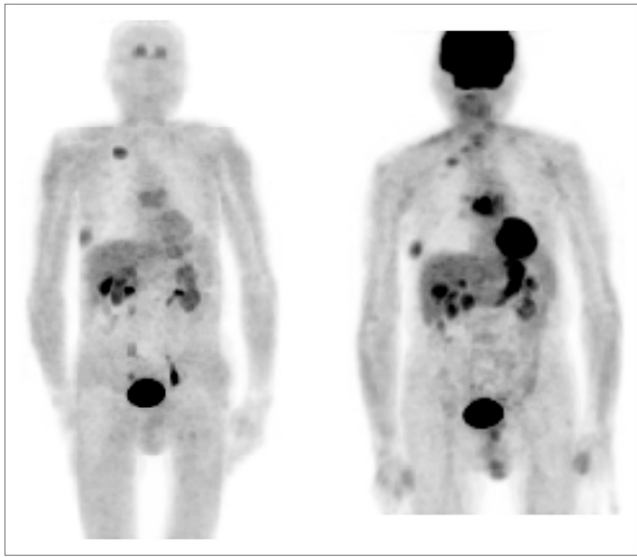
MTC patient with uptake on both ^{18}F -DOPA PET (left) and ^{18}F -FDG PET (right). On ^{18}F -DOPA PET, lesions are seen in right supraclavicular region and right hemithorax, and there is slight uptake in subcarinal region. In abdomen, there are several lesions with faint uptake. Also on ^{18}F -FDG PET, uptake is seen in right supraclavicular region and right hemithorax, and there is intensive uptake in subcarinal region. Furthermore, several lesions are seen in liver region. Calcitonin and CEA levels were highly elevated (23,236 ng/L [reference, 0.3–12 ng/L] and 2,144 $\mu\text{g/L}$ [reference, 0.5–5.0 $\mu\text{g/L}$]), and calcitonin and CEA doubling times were short (13 and 12 mo, respectively). Patient died of progressive disease 29 mo after scans were performed.
